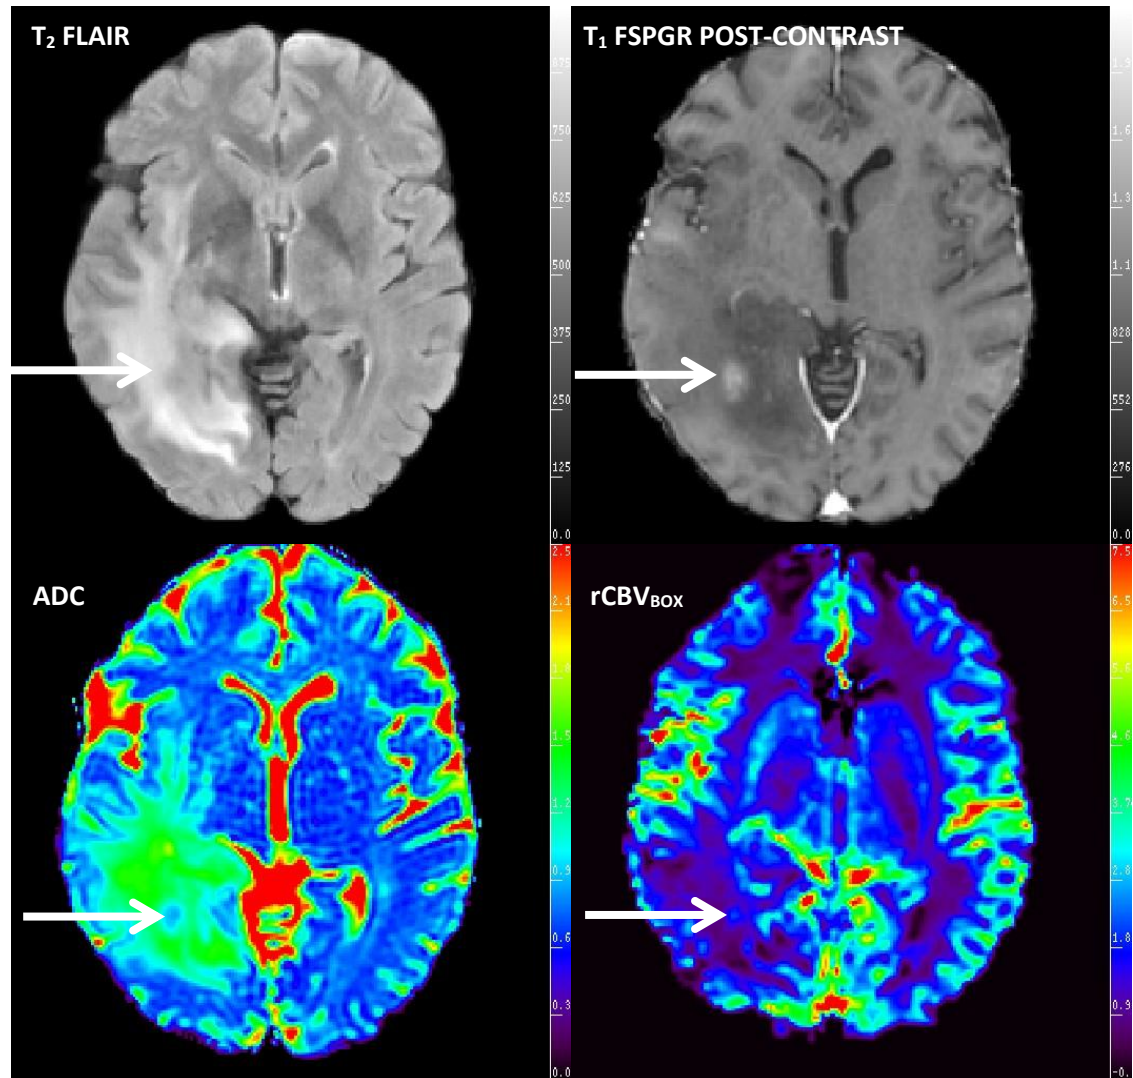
This example shows a study patient with a WHO grade II lesion, classified using tissue sampling from a partial resection ( $ADC=0.25 \times 10^{-3} \text{mm}^2 \text{s}^{-1}$  and  $rCBV_{\text{BOX}}=0.75$ ). However, MR shows contrast enhancement in the deep aspect of the tumour coupled with decreased ADC and a small region of increased  $rCBV_{\text{BOX}}$ . All the MR imaging suggests transformation to a higher grade however, it is most likely that the enhancing tissue portion was never sent to the neuropathologist. During the clinical scans at 6, 9 and 12 months, various small enhancing foci around the surgical cavity have also been observed.
